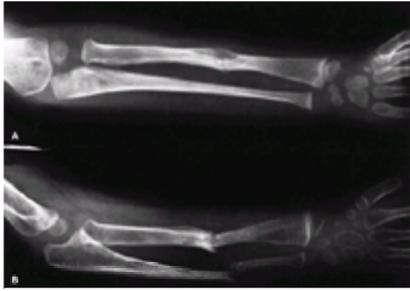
Neurofibromatosis in a 3-year-old patient. The radiograph shows progressive pseudarthrosis of the radius and ulna after a pathologic fracture. A: Fracture through the cystic lesion of the radius and thinning of the mid ulna. B: After 10 months of cast immobilization, pseudarthrosis affects the radius and ulna. (From ref. [1](#), with permission.)
